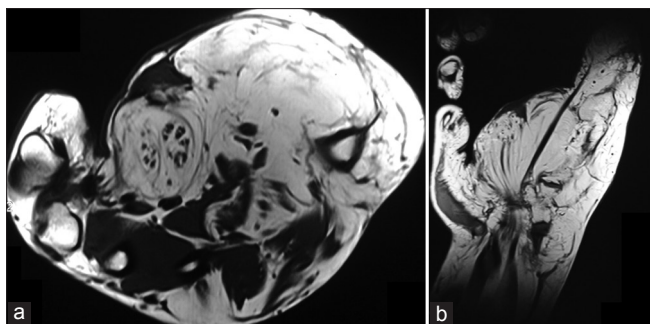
(a) MRI hand (cross-sectional view). (b) MRI hand (coronal)
